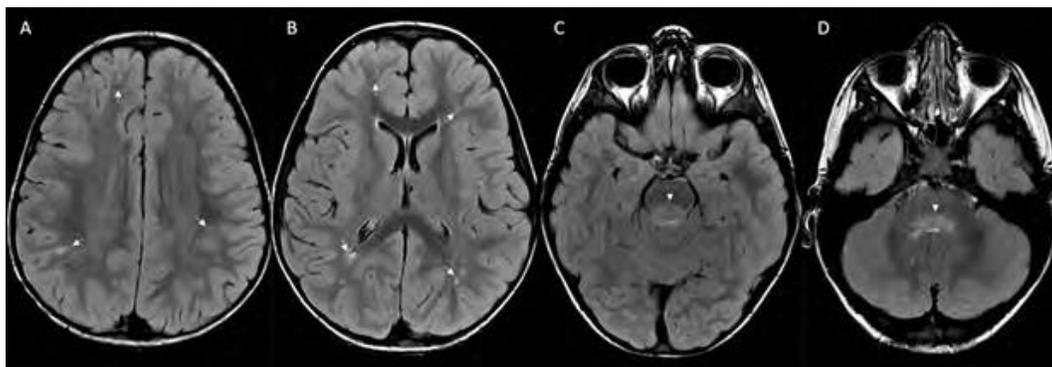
Brain MR imaging on the first day of hospitalization. Axial T2-weighted FLAIR image at the level of the centrum semiovale shows abnormal bilateral punctate subcortical white matter hyperintense signals (white arrows) in frontal and parietal regions (A). Axial T2-weighted FLAIR image at the level of basal ganglia shows abnormal bilateral punctate subcortical white matter hyperintense signals (white arrows) in the frontal and parieto-occipital regions (B). Axial T2-weighted FLAIR image at the level of rostral pons shows a subtle abnormal hyperintense signal (arrowhead) in dorsal pons (C). Axial T2-weighted FLAIR image at the level of caudal pons shows an abnormal hyperintense signal (arrowhead) in dorsal pons (D). All abnormal hyperintense signals were not associated with pathologic contrast enhancement.
